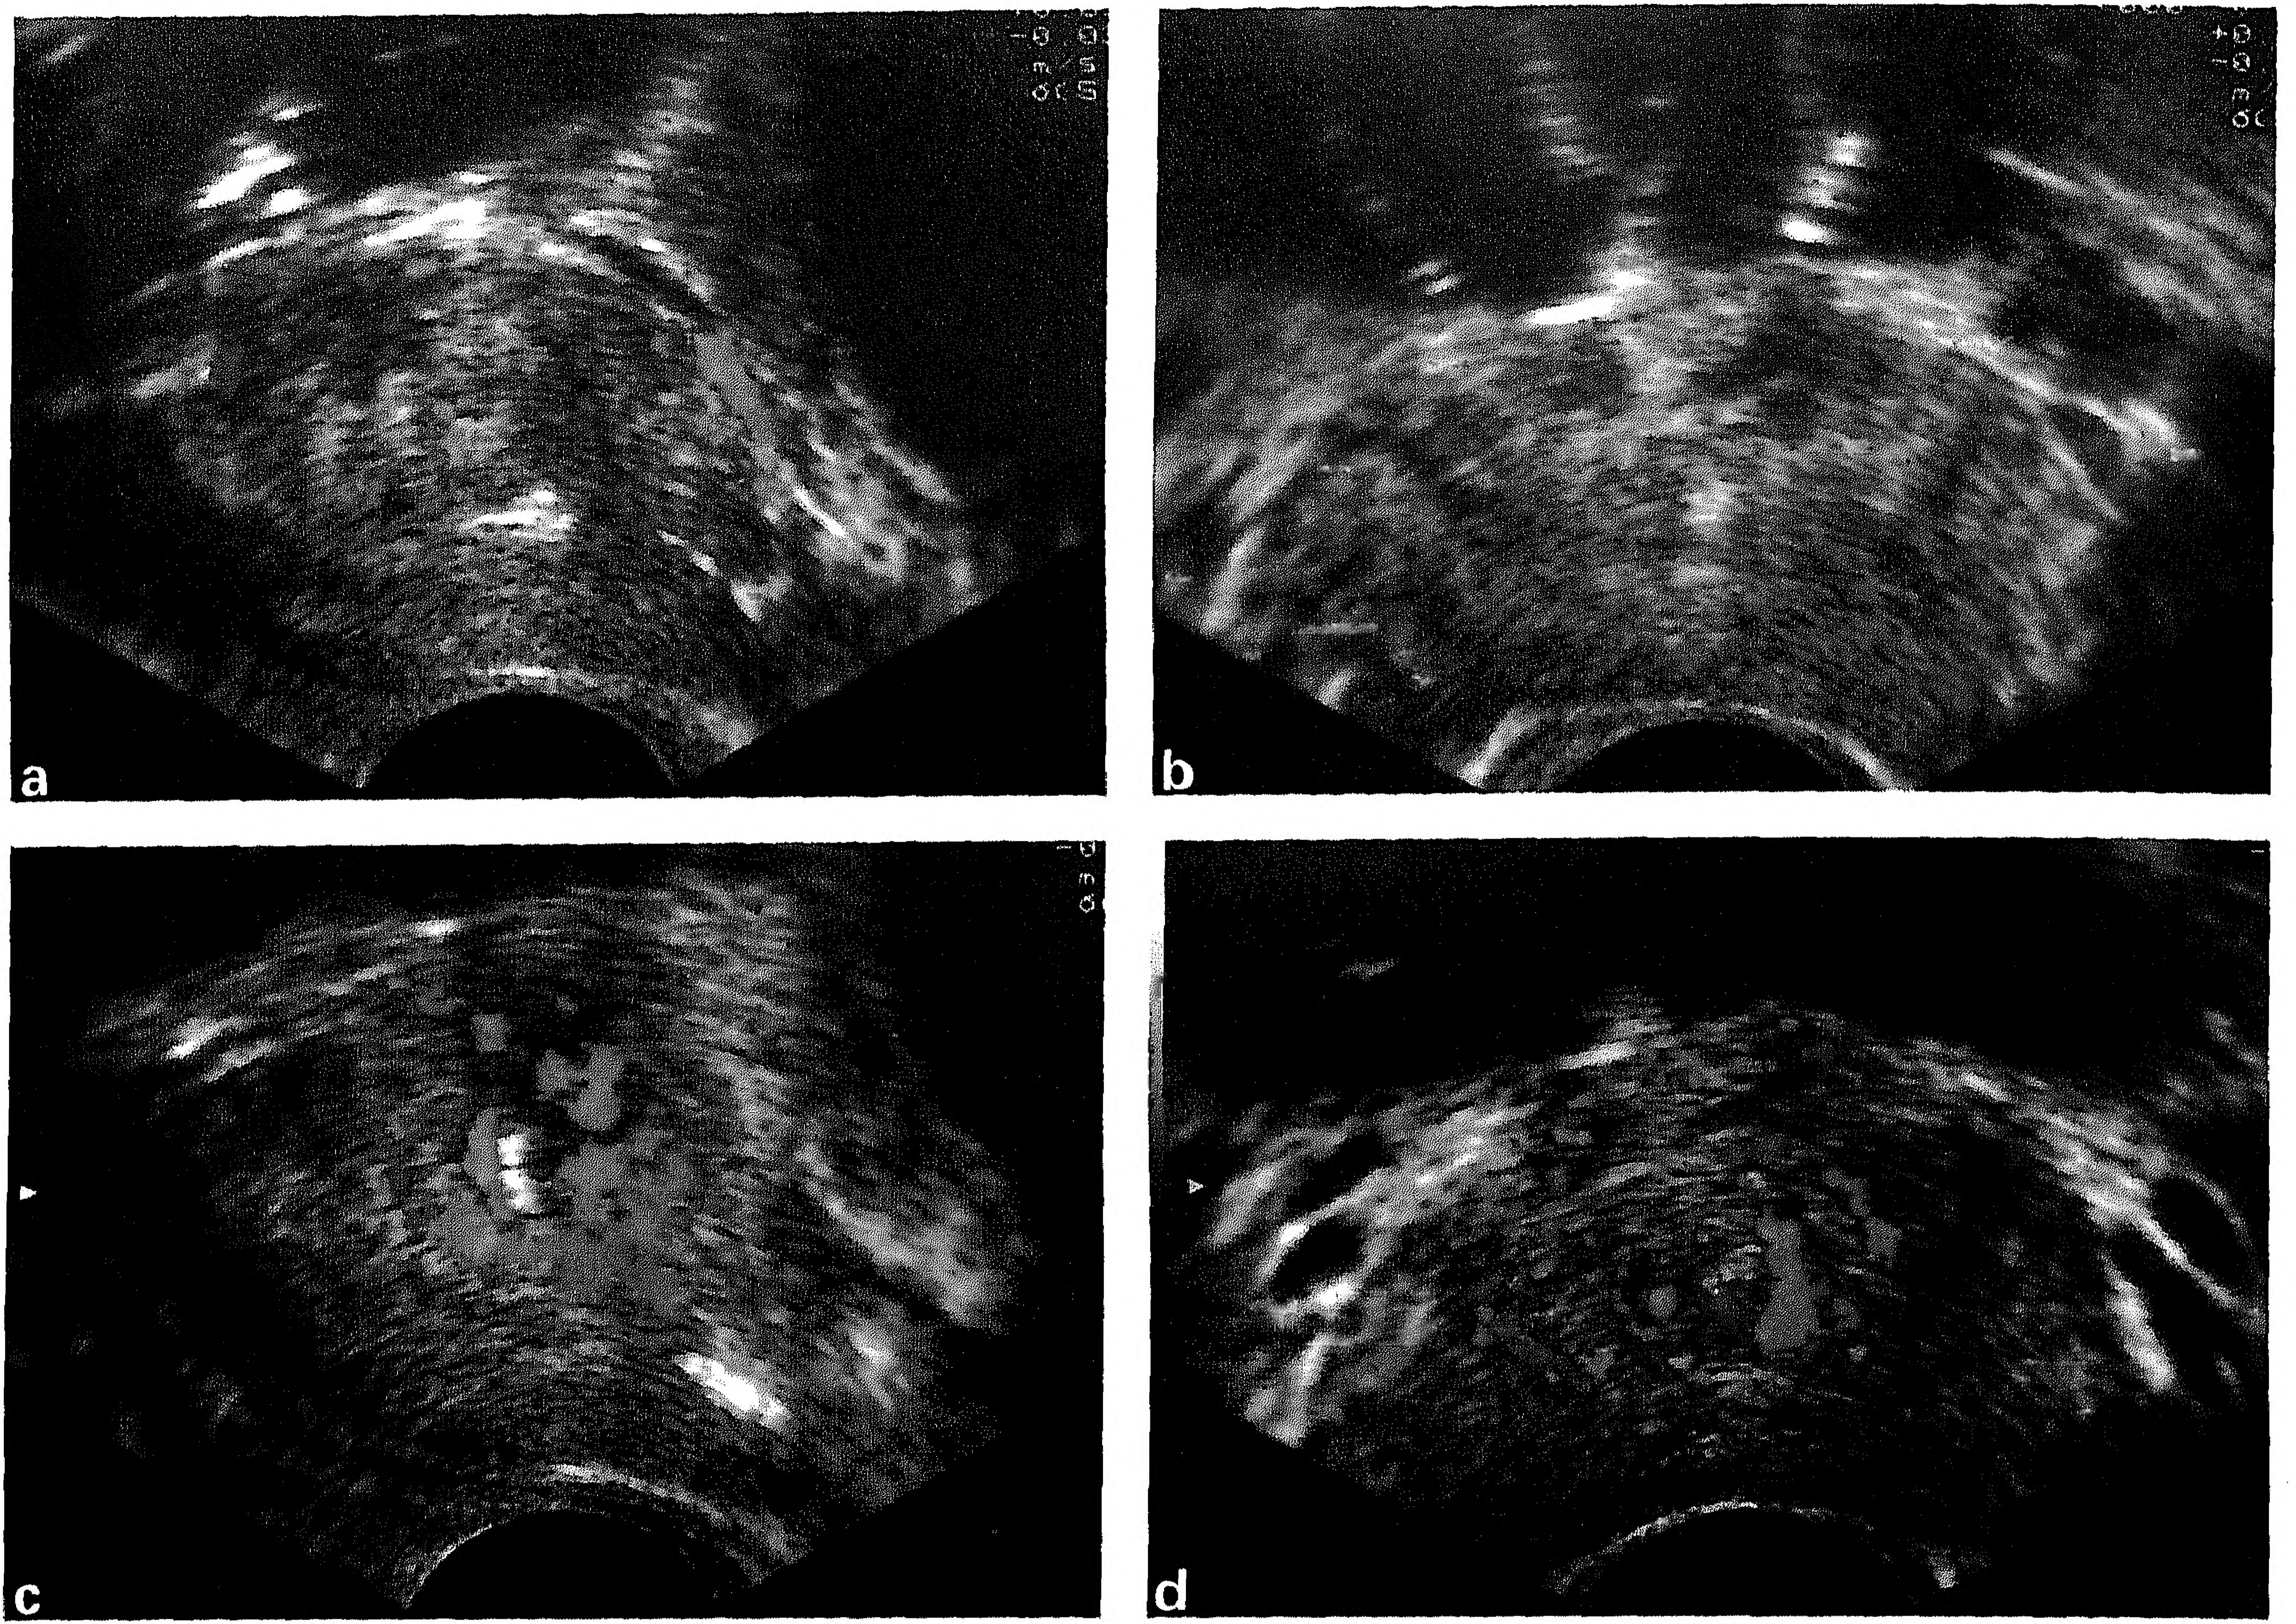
Ultrasonograms of the prostate with colour Doppler mapping using the Hitachi EUB555 with a transrectal probe (V33W; 6.5 MHz multipurpose endoprobe), before (a, longitudinal and b, transverse) and immediately after TUMT (c, longitudinal and d, transverse).
